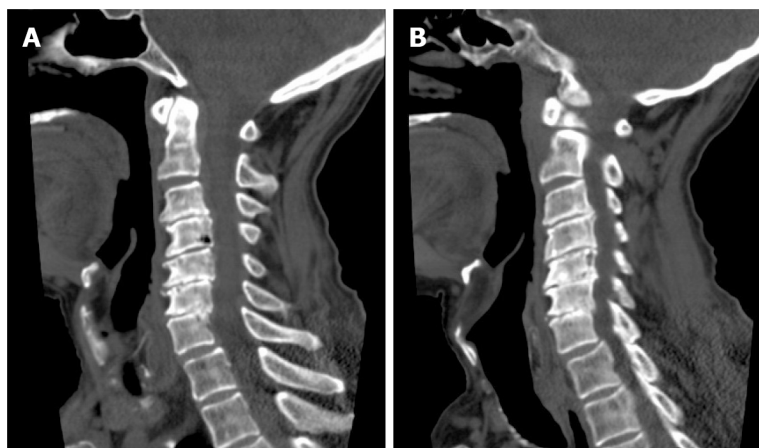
Computed tomography of the cervical spine. A: C4 vertebral body destruction; B: C5-7 vertebral body assimilation.
